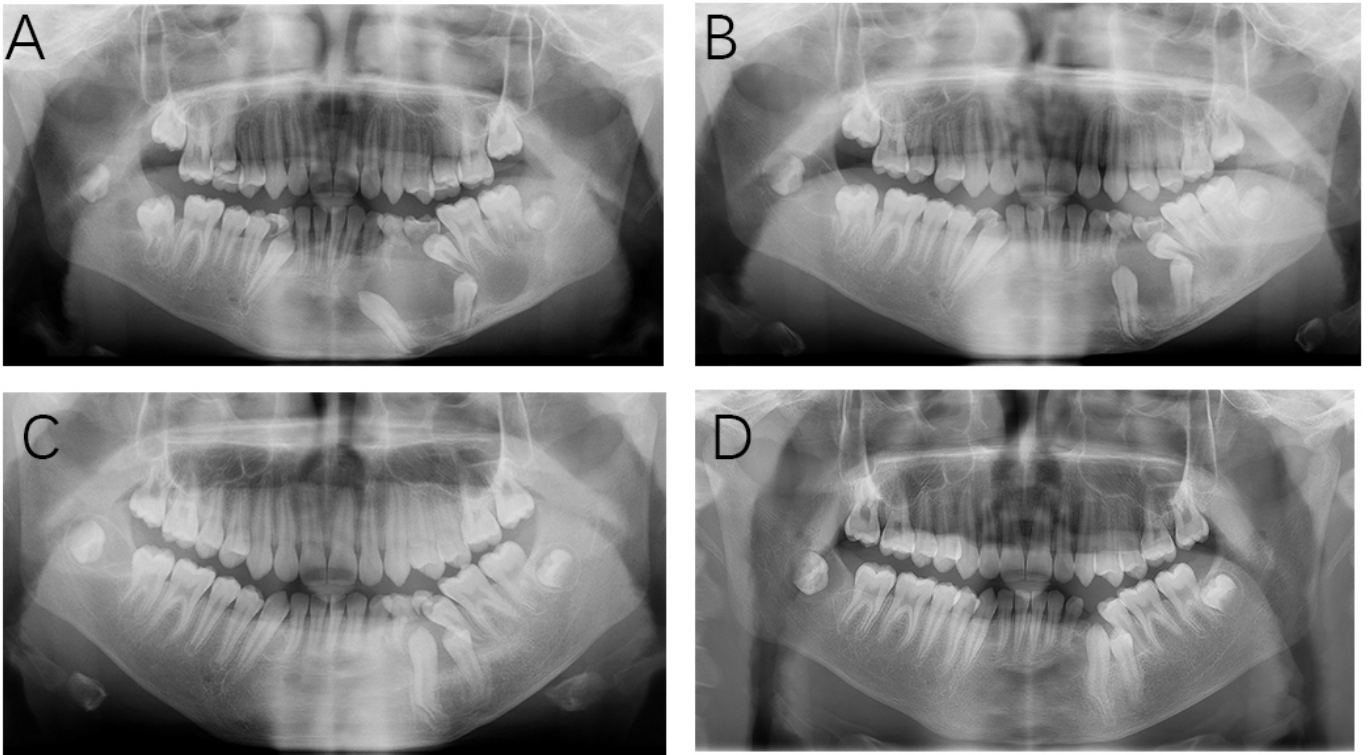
Panoramic radiographs during treatment. (A–D) After the marsupialization, the panoramic radiograph demonstrated the new bone formation and the reduction of lesions.
